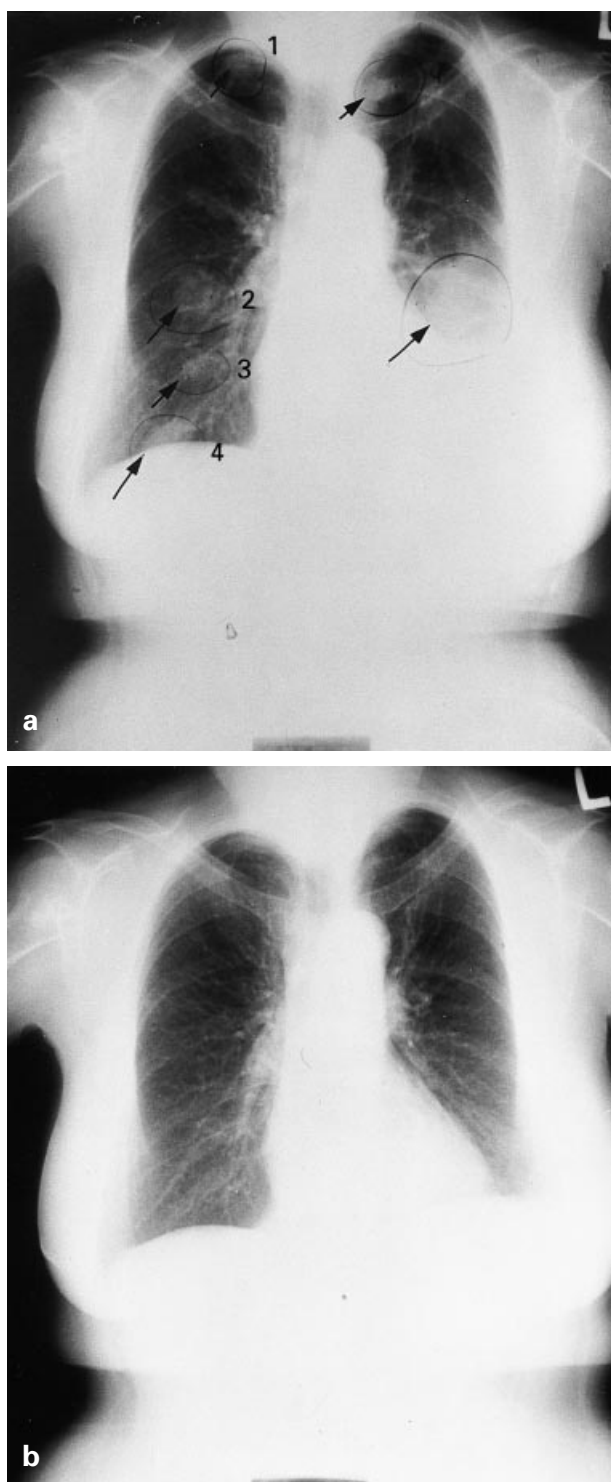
(a) A chest X-ray showing multiple metastases in patient no. 3 on inclusion in the study. (b) From 7.4 months after enrolment the patient had a CR and this was maintained until the end of the study (June 1996).
